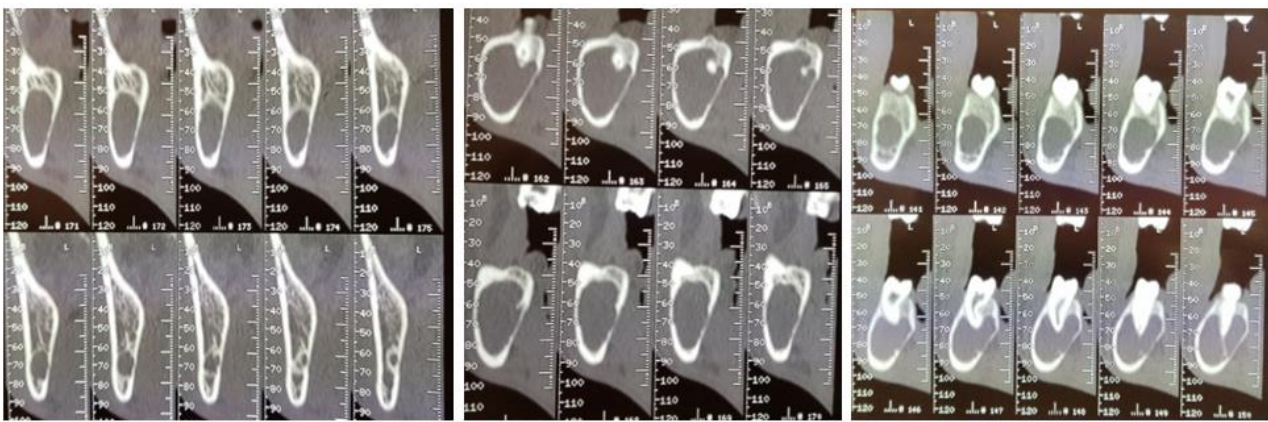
Patient 2: CT examination of the mandible: hypodensity filling the entire horizontal branch with repression of the mandibular canal towards the lingual cortex. The dental roots appear to be directly embedded in the lesion
